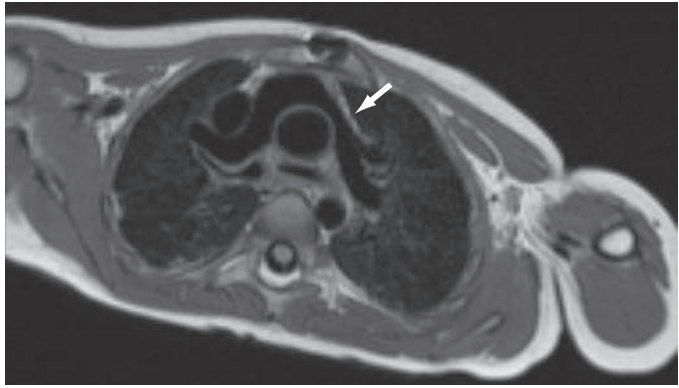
Magnetic resonance imaging scan of a patient after the arterial switch operation, showing the branch pulmonary arteries straddling the ascending aorta after the LeCompte maneuver. The arrow indicates stenosis of the left pulmonary artery as it passes the aorta.
